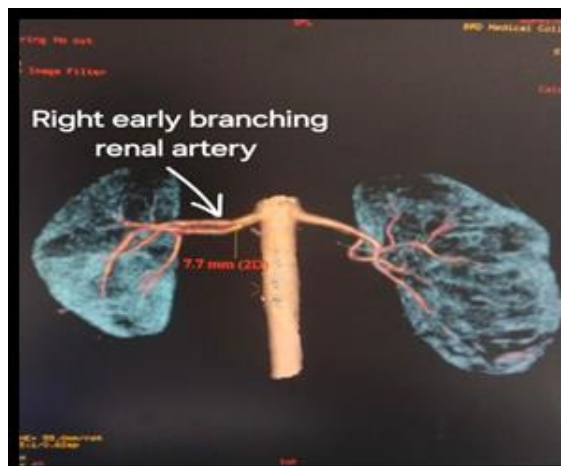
Computed tomography arterial phase images showing right early branching renal artery
